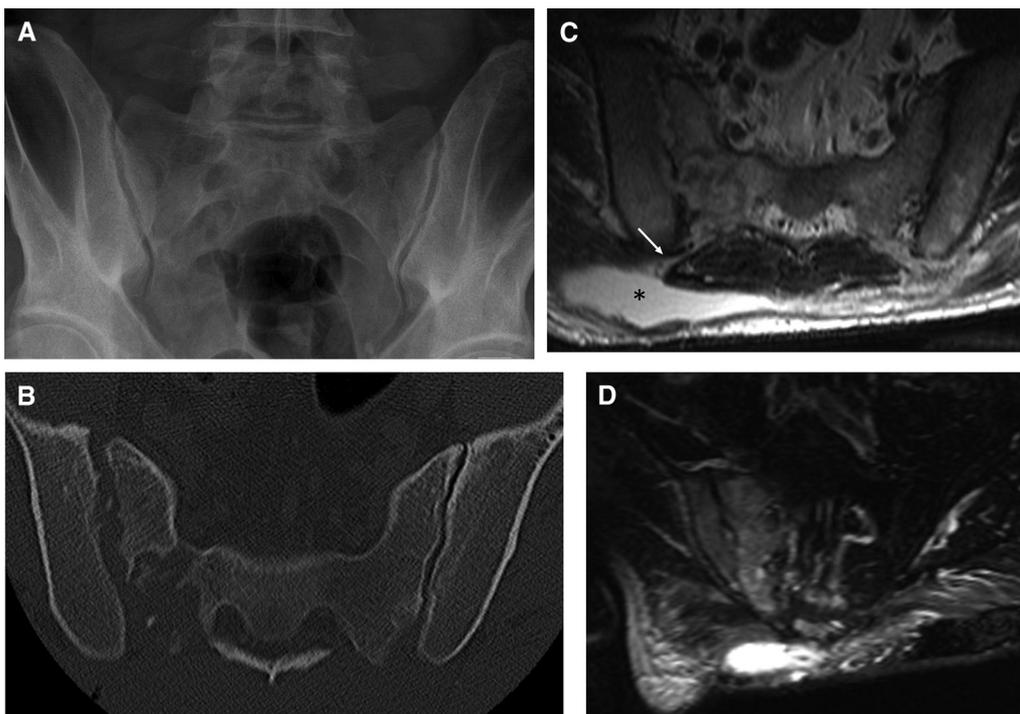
Unilateral right tuberculous sacroiliitis in a 40-year-old man on immunosuppressive therapy for inflammatory bowel disease with repeated presentations for right gluteal pain. (A) Initial pelvic radiograph revealed no significant abnormality. (B) Follow-up axial computed tomography pelvis was performed 4 weeks later showing widening, erosion and destruction of the right sacroiliac joint. (C) Axial T2-weighted magnetic resonance imaging shows a discharging sinus from the joint (white arrow) leading into a subcutaneous fluid collection (asterisk) consistent with infective sacroiliitis and adjacent abscess formation. Cultures from aspirates grew *mycobacterium tuberculosis*. (D) Coronal short tau inversion recovery image shows bone marrow and soft tissue oedema surrounding the right sacroiliac joint.
